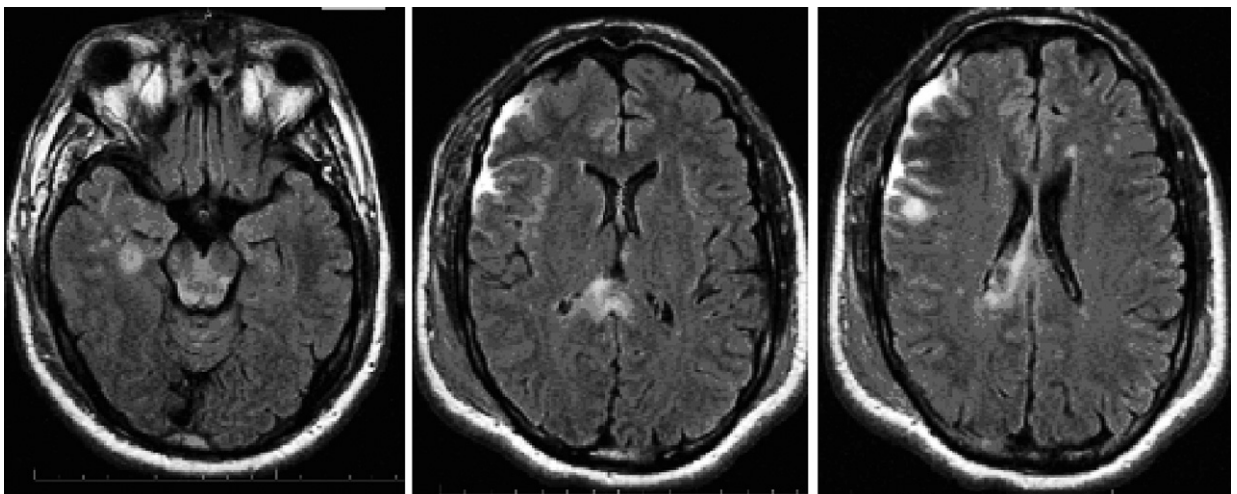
Axial FLAIR MRI scans show foci of hyperintense regions in brainstem, corpus callosum, and gray–white junctions representing diffuse axonal injury.
